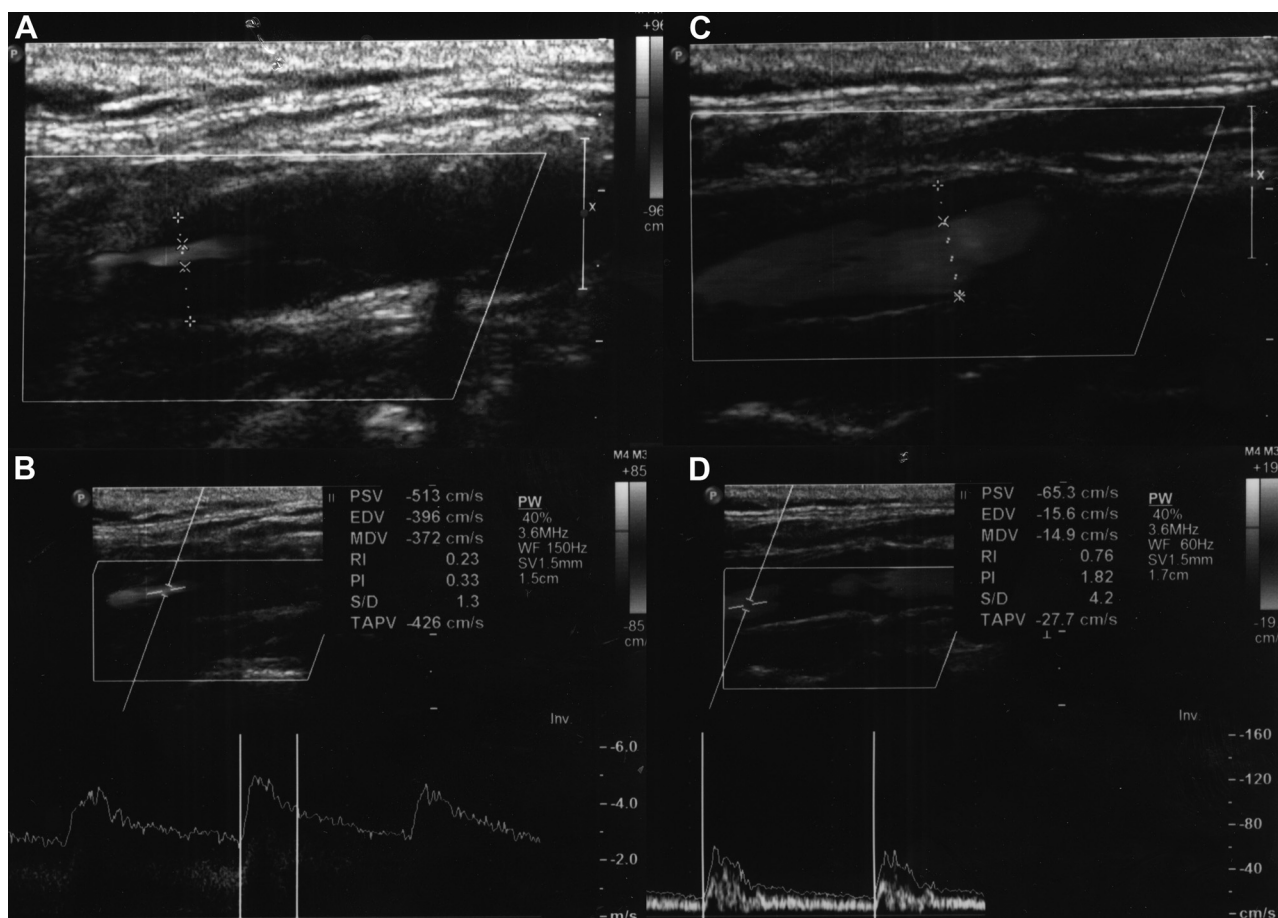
Ultrasound (2-dimensional) images of left (A) and right (C) internal carotid arteries (ICAs) and Doppler waveforms of left (B) and right (D) ICAs showing severe stenosis and increased peak systolic velocity (513 cm/s) of the left ICA and normal peak systolic velocity (65.3 cm/s) of the right ICA.
